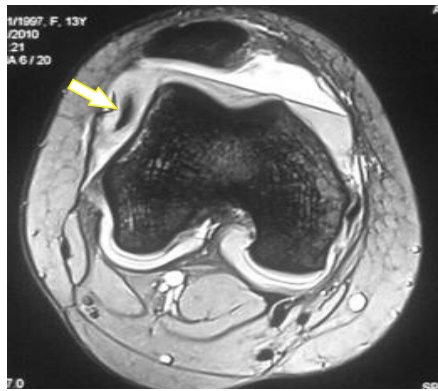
MRI Scan of knee showing a small loose body in the lateral gutter (Arrow)
